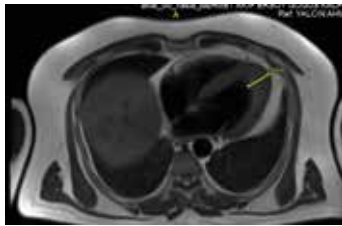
Cardiac MRI of the patient demonstrating apical hypertrophy.
